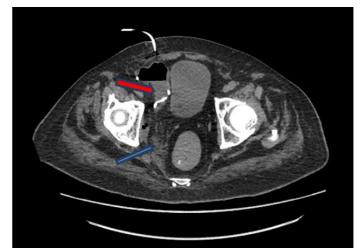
10 days after surgery. Posterior segment of the abscess cavity (blue arrow): inflammatory activity, remnant pus, cavity with air, well-drained area. Anterior segment of the cavity: undrained area, an image of an abscess (red arrow), pigtail catheter introduced under CT guidance (white contrast appearance).
